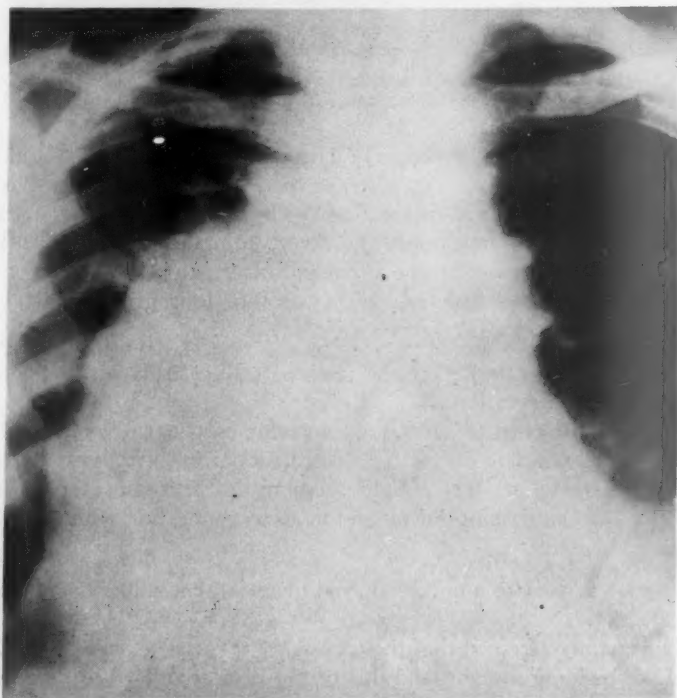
The posterior-anterior roentgenogram of the chest of a 22 year old male who had marked symptoms of dyspnea and other signs of mediastinal compression.
